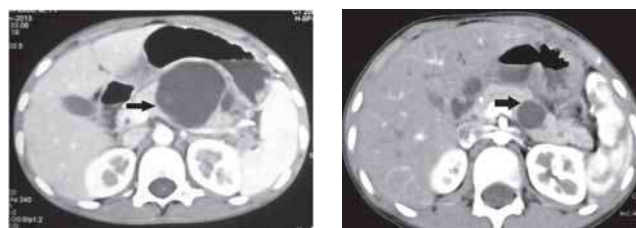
Computed tomogram (axial section) of a 7-year-old boy who presented 7 days after handlebar injury to the abdomen. (A) On admission it showed a large (6×6 cm) acute fluid collection around the body of pancreas (arrow). (B) After 6 weeks of non-operative treatment considerable resolution occurred (arrow).
